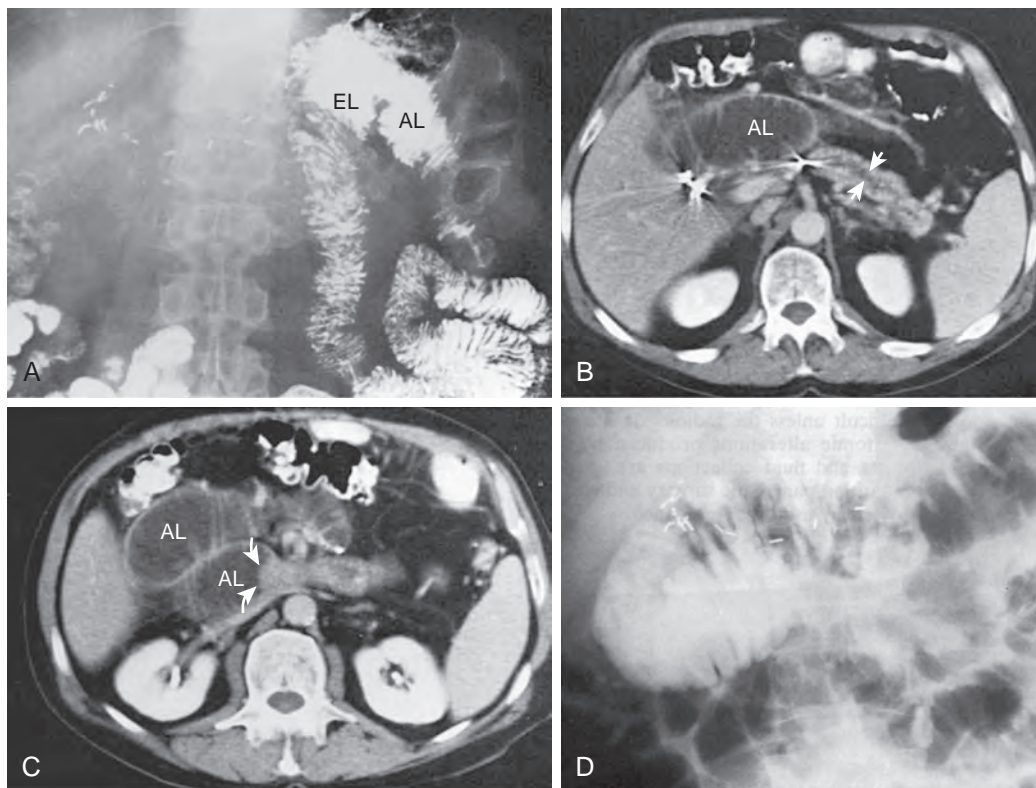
Afferent loop obstruction. Obstructed afferent loop caused by tumor recurrence after Whipple procedure for carcinoma of the pancreatic head. A. Barium study shows an antiperistaltic Billroth II gastrojejunostomy. The efferent loop (EL) fills normally. The distal portion of the afferent loop (AL) is also opacified. B. CT scan at the level of the pancreas shows the dilated afferent loop. The pancreatic duct (*arrows*) is dilated as well. C. More caudal scan shows the dilated afferent loop and tumor recurrence (*arrows*). D. Afferent loop dilation and retention of contrast medium were confirmed by endoscopic retrograde pancreatography.
